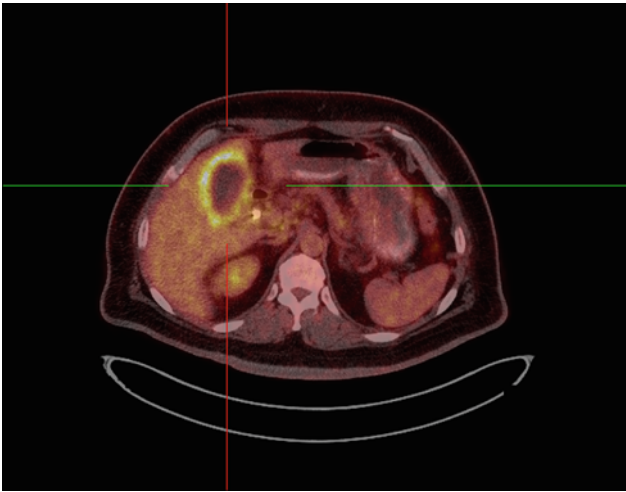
54 year-old male with a history of cholangiocarcinoma with liver metastases. PET/CT scan was indicated for the evaluation of residual disease following completion of chemotherapy. Fused axial ^{18}F -FDG PET/CT image demonstrates intensely FDG-avid thickening noted along the gallbladder with the highest SUVmax of 9.7. The wall thickening measuring up to 1 cm is consistent with persistent disease presence
